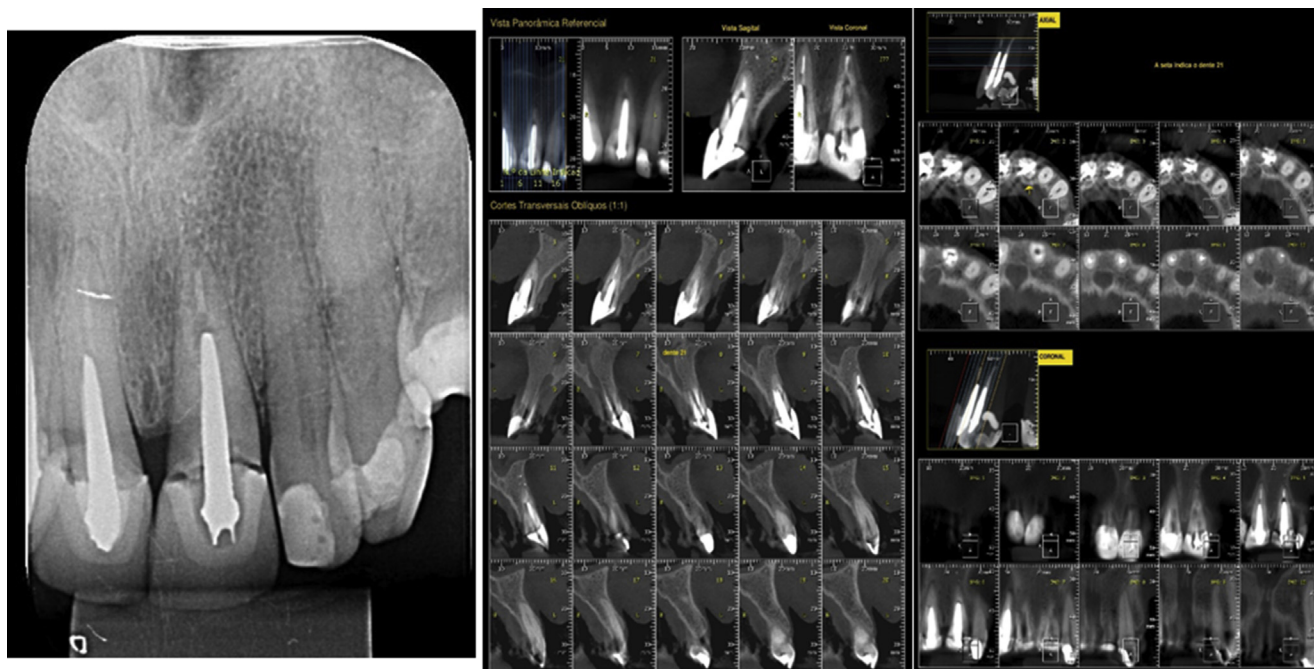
Example of the cases chosen for the study. Periapical radiograph was used for questionnaire 1 (Q1), and CBCT multiplanar reconstruction was used for Q2. A clinical history followed both images, eg, “A 50-year-old male patient requested a dental appointment to evaluate his left maxillary incisor. The patient had no history of systemic disease. There was no gingivitis, and periodontal probing depth was 3 mm at all sites. The tooth had a fixed prosthesis with a post. The patient reported tenderness on percussion. Root canal treatment had been performed four years previously. The patient had suffered a sports-related dental trauma. During clinical examination, vertical and horizontal percussion sensitivity tests were positive. The patient did not have edema or pain on apical palpation. The tooth is not mobile and there is no sinus tract present”.
